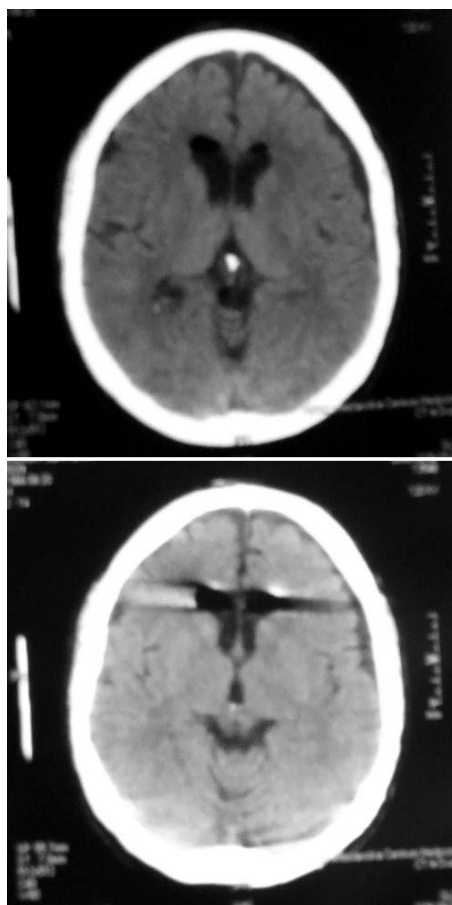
CT scan depicts air presence in the cerebral lateral ventricles
